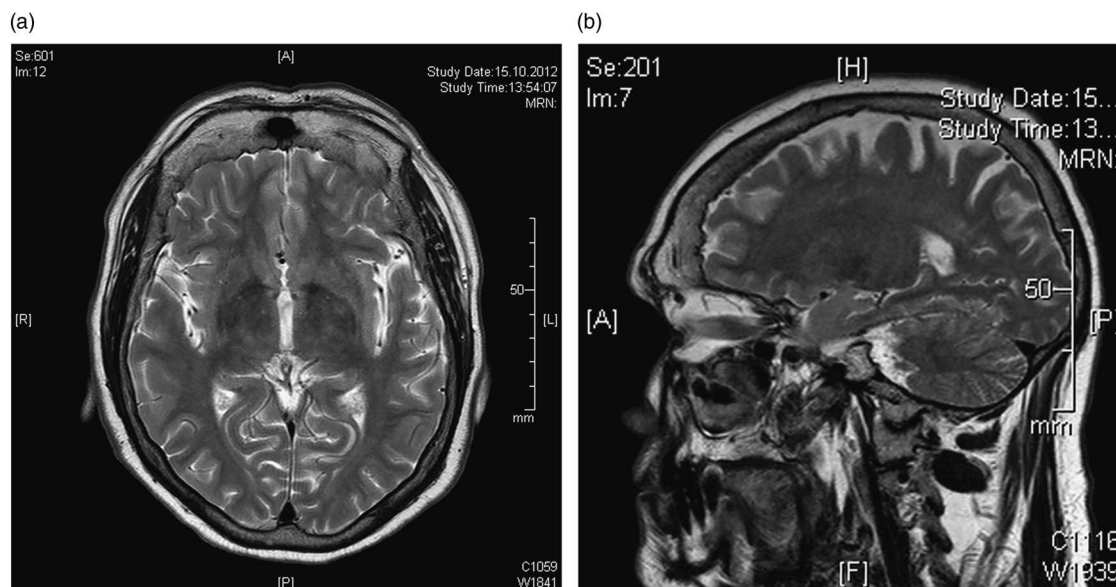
(a, b) Cranial magnetic resonance imaging. Sagittal and axial T2-weighted images. Symmetric thickening of the inner table of the frontal bone, also vascular white-matter lesions. Glial defect at posterior left ventricle.
